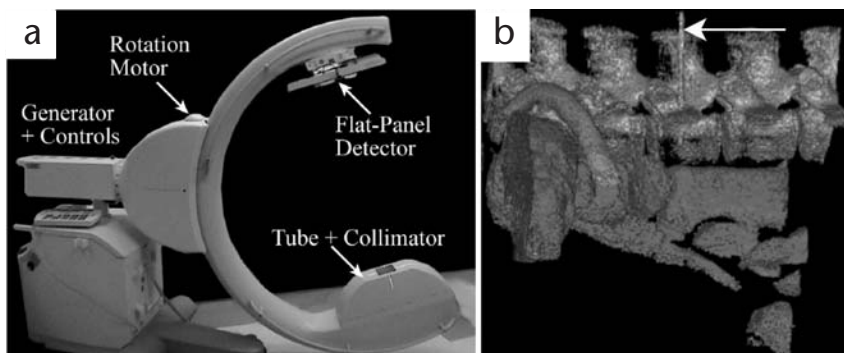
(a) A mobile cone beam CT with large, flat panel detector was used for placing fibers into the spine. (b) Rapid 3-D reconstructions of the spine and surrounding soft tissues allows for accurate intraoperative navigation.
